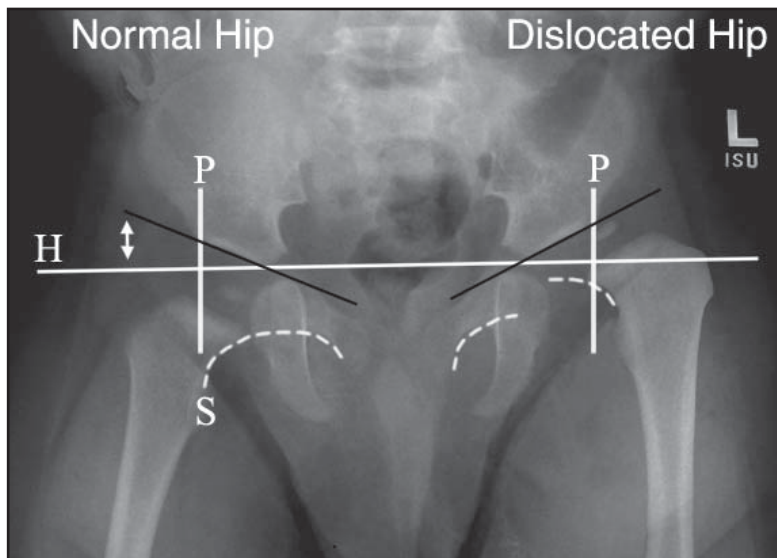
Reference lines used to evaluate DDH. Several radiographic measurements have been used to evaluate DDH. This radiograph demonstrates some of those lines and angles. The horizontal line labeled H is the Hilgenreiner line, drawn between the triradiate epiphyses. The 2 lines labeled P are the Perkin lines. They bisect the Hilgenreiner line at right angles, dividing each hip into 4 quadrants. In a normal hip, the proximal medial portion of the femur should be in the lower medial quadrant. If the head of the femur has begun to ossify, it also should be visualized in the lower medial quadrant. The double arrow signifies the acetabular index, which is the angle between the Hilgenreiner line and the triradiate epiphyses and acetabulum. This angle decreases with age and should be less than 20° by the age of 2 years. The Shenton line (S) is drawn from the medial border of the femoral neck to the inferior border of the pubic rami and should create a smooth arc. If the arc is disrupted, as is shown in the left hip, it indicates a hip subluxation or dislocation.
